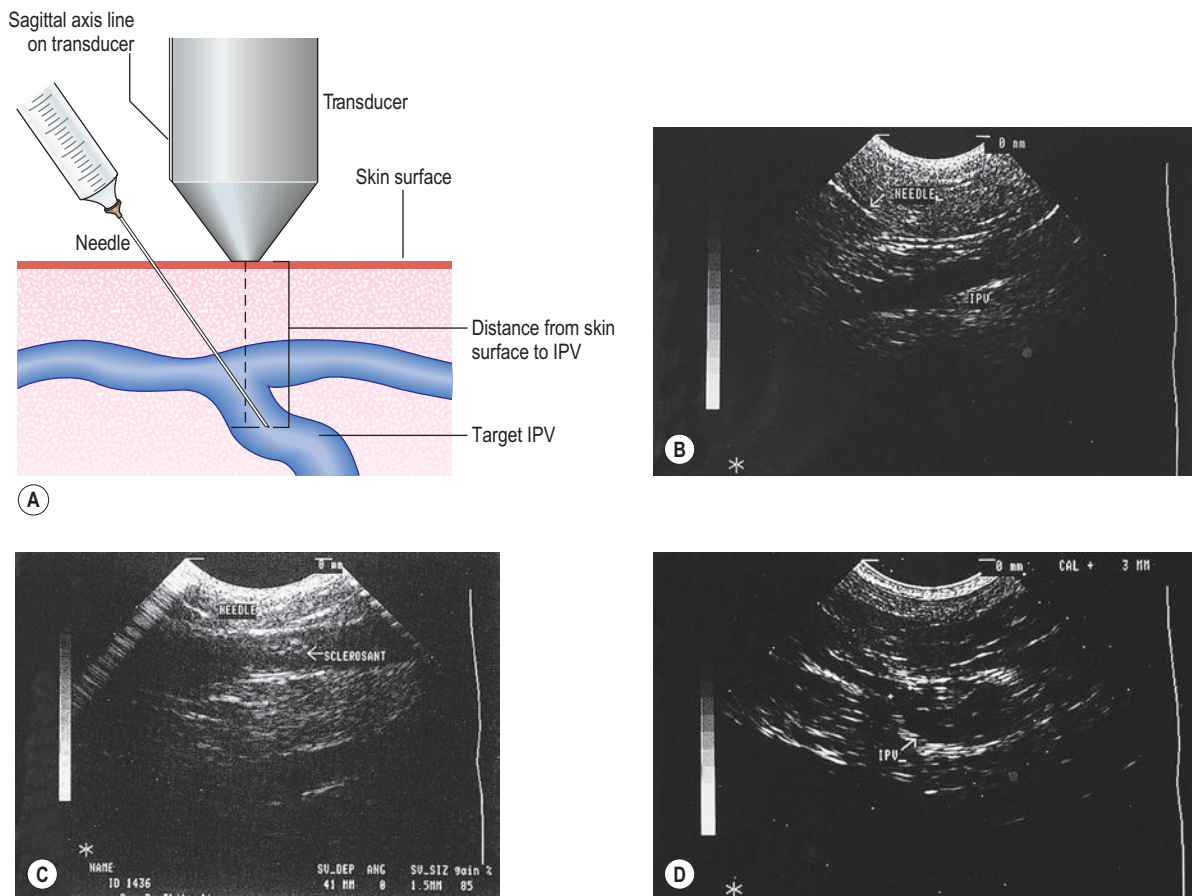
A, Needle is inserted close to the transducer tip and along the sagittal plane of the transducer. Depth of target incompetent perforator vein (IPV) is measured on the B-mode image from skin surface to segment of IPV. B, B-mode ultrasound image showing needle approaching IPV. C, B-mode ultrasound image of needle located in vein with sclerosant flowing in the vein. D, Postinjection B-mode image of IPV showing vessel spasm. (From Thibault PK, Lewis WA. *J Dermatol Surg Oncol* 1992;18:895.)
